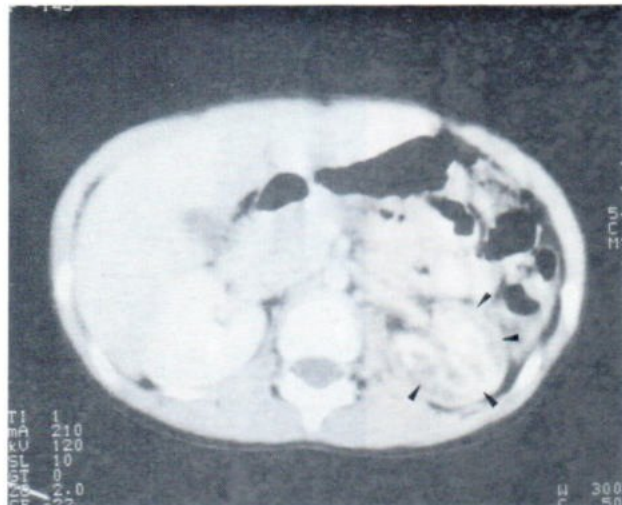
CT of the abdomen at the level of the kidneys showing a cortical rim nephrogram (arrowheads) in the left kidney with uneven distribution of contrast in the parenchyma. The kidney size is normal. Marked reduction in arterial perfusion of the left kidney was seen on duplex ultrasonography (not shown)
